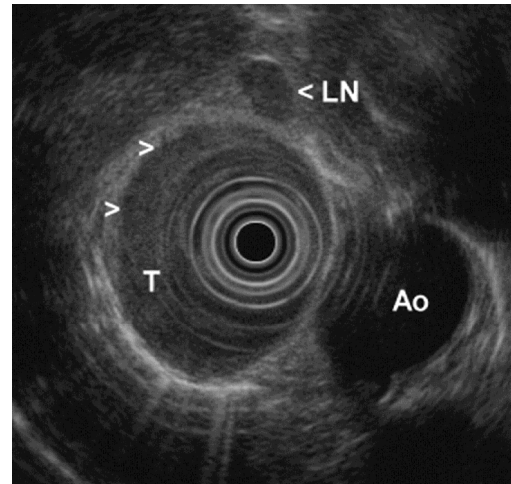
Oesophageal ultrasound showing tumour (T) and surrounding adenopathy (LN) in relation to the Aorta (Ao)
